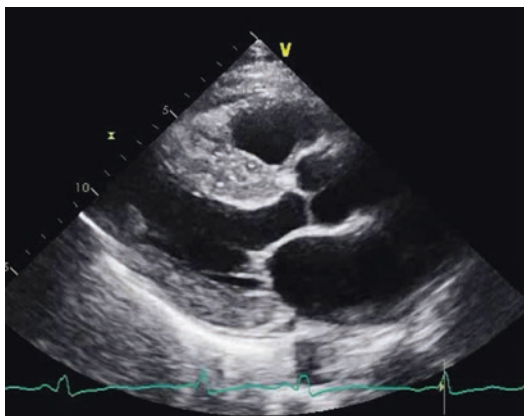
Parasternal long axis view of the heart demonstrating left ventricular hypertrophy and speckled pattern of myocardium “classic” for cardiac amyloidosis
